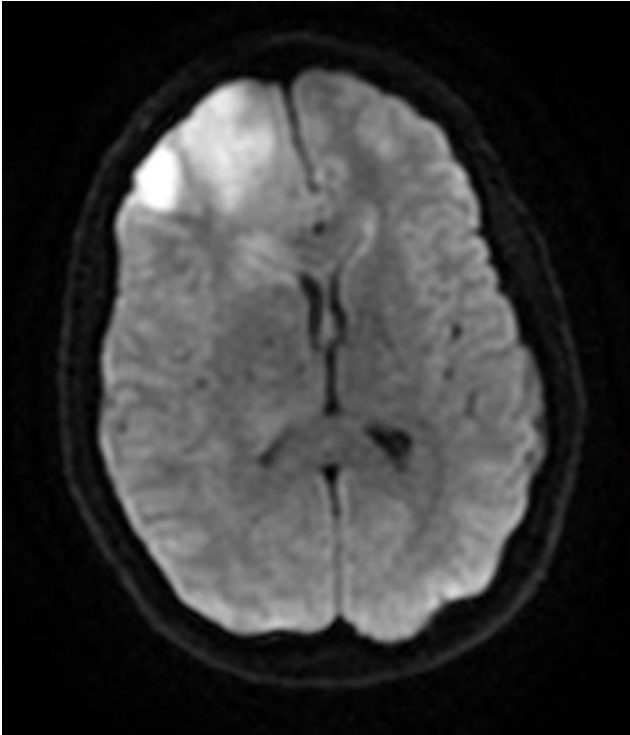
T2-weighted MRI of the right frontal lobe PCNSL without (left) and with contrast agent (right).
